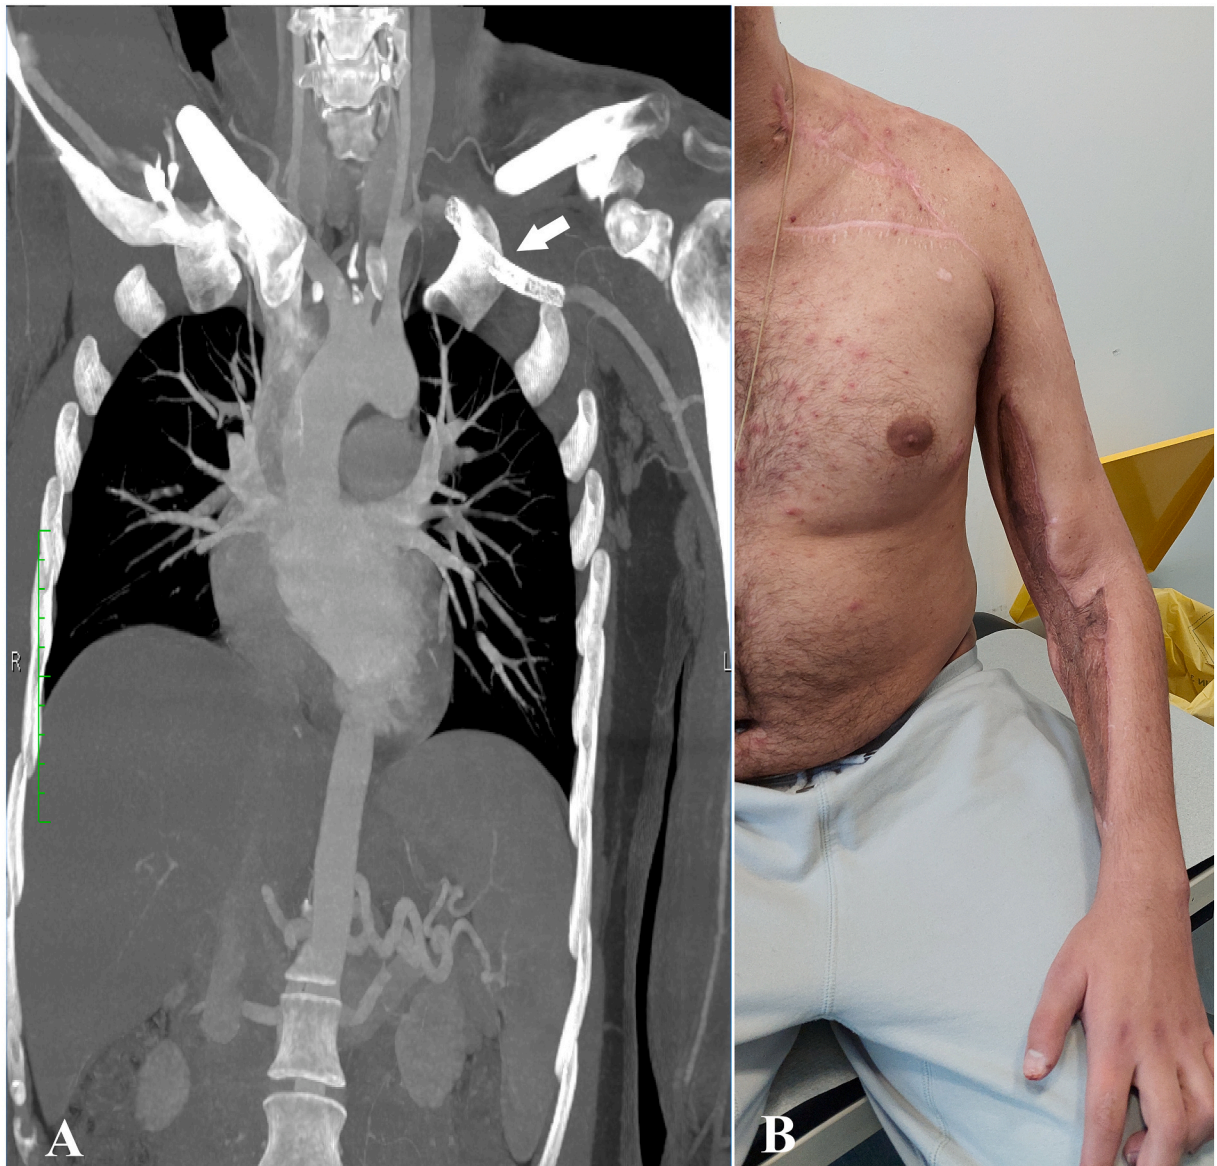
Follow-up six months after the accident. (A) Computed tomography where the white arrow indicates the patent arterial bypass. (B) Photograph of the left arm being viable but significantly affected.
